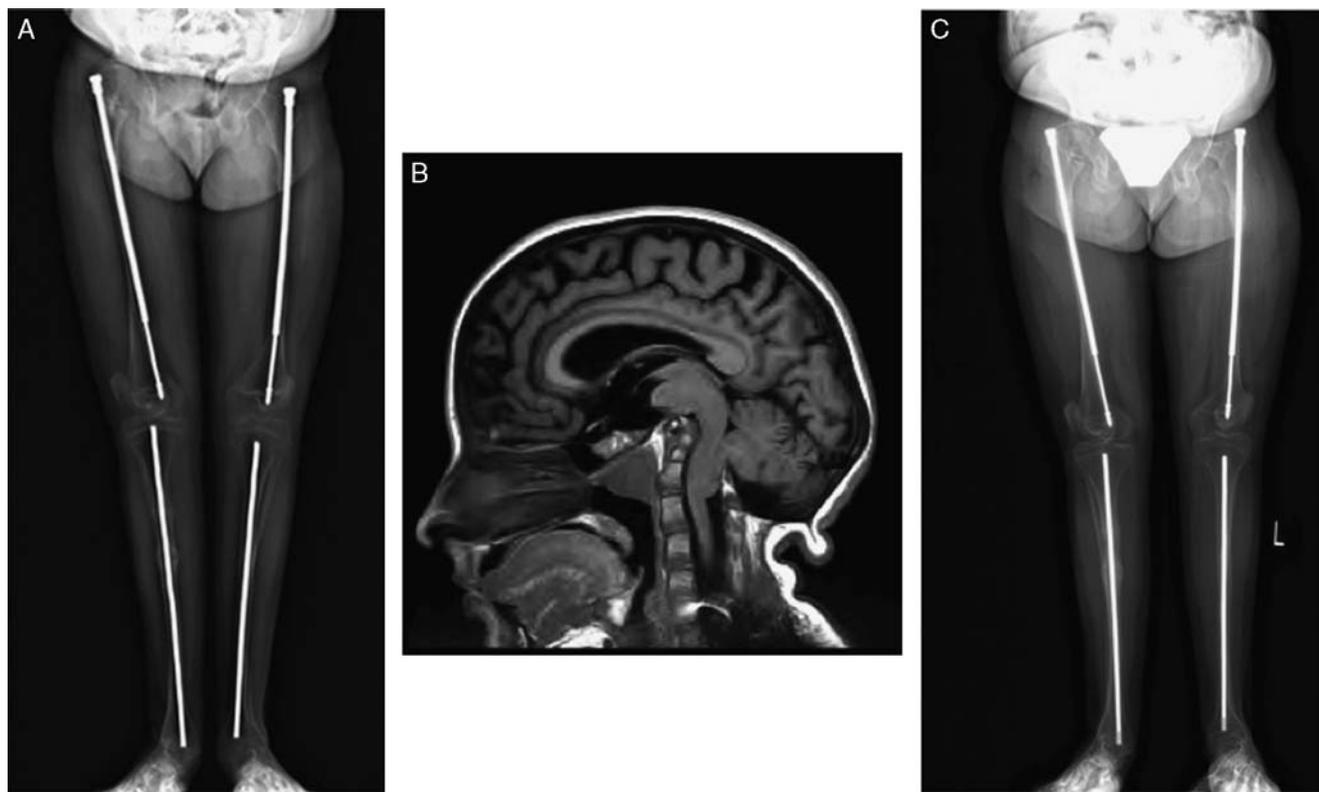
A, Anteroposterior radiographs of lower extremities showing bilateral femur Fassier-Duval rods and bilateral tibial K-wires in an 18-year-old male patient with osteogenesis imperfecta before the magnetic resonance imaging (MRI) evaluation. B, MRI of the cervical spine in the same patient shows basilar invagination without artifact. C, Anteroposterior radiographs of lower extremities of the same patient after the MRI evaluation showing no migration of implants.
